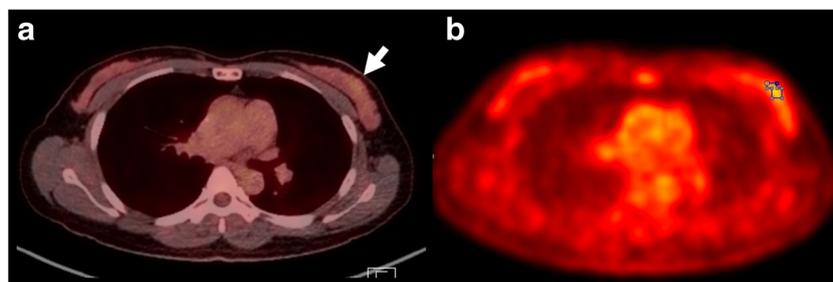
ER-positive/HER2-negative invasive ductal carcinoma in a 43-year-old woman. The pathologic invasive tumor size was 1.2 cm without lymph node metastasis (pT1N0). The nuclear grade was 3, and the IHC expression profiles were ER 60 %, PR 5 %, HER2 score 1+, and Ki-67 10 %. a The preoperative ^{18}F -FDG PET/CT image shows low ^{18}F -FDG
